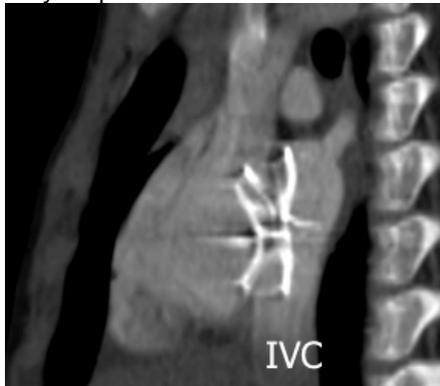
CT scan showing the device protrusion above the IVC.
